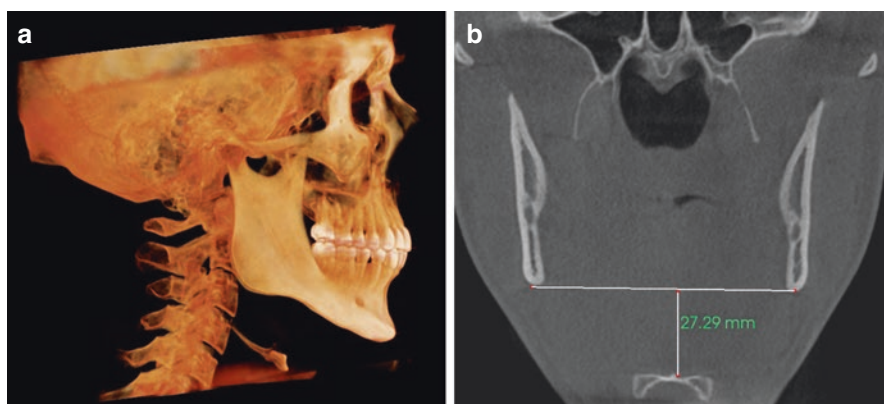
(a) CBCT 3D lateral reformation shows a low hyoid position. (b) Coronal view shows a method for measuring the distance of the body of the hyoid bone to the level of the inferior border of the mandible
